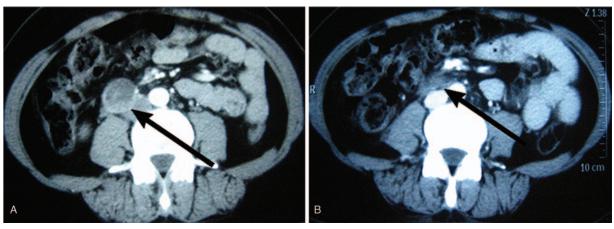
Constructed CT scans before starting sunitinib and after 2 months of 4/2 schedule and 4 months of 2/1 schedule. (A) After the first surgery before starting sunitinib. (B) Achievement of complete response (CR) after 2 months of 4/2 schedule and 4 months of 2/1 schedule. CR=complete response.
